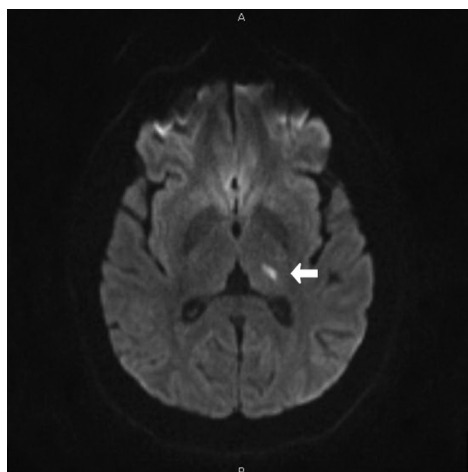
Diffusion-weighted magnetic resonance imaging of the brain shows lacunar infarct in the left thalamus (arrow).
